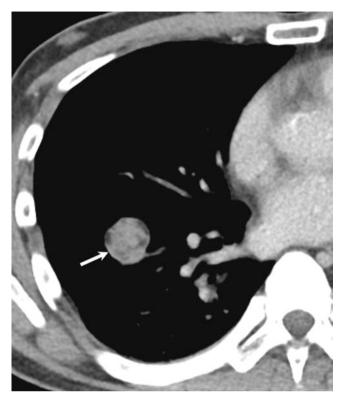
A 30-year-old female with hamartoma. Contrast-enhanced axial CT thorax in soft tissue window shows a fat containing solitary pulmonary nodule in the right lung (arrow)
